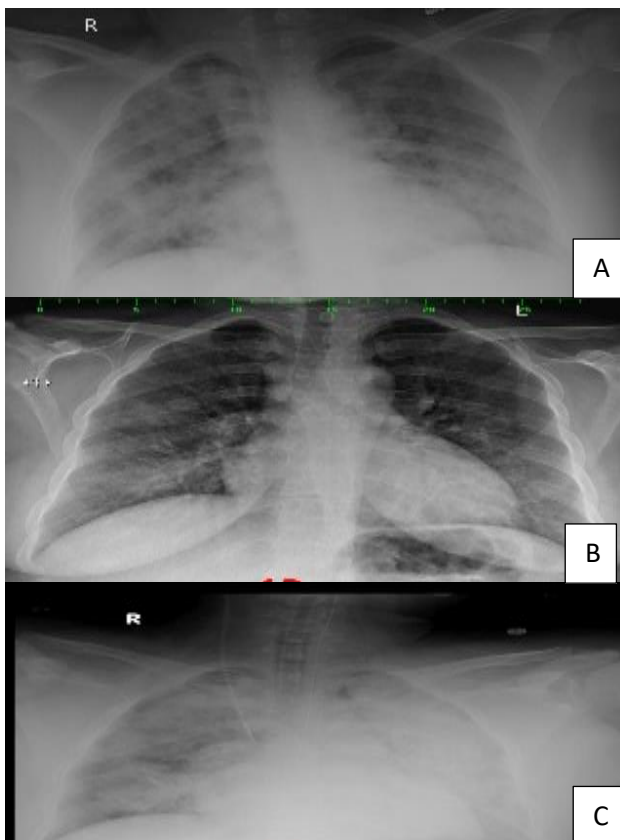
(A-C): Chest radiograph with bilateral infiltrates during first admission, post-treatment radiograph with complete resolution of infiltrates and chest radiograph during second admission with bilateral infiltrates.
